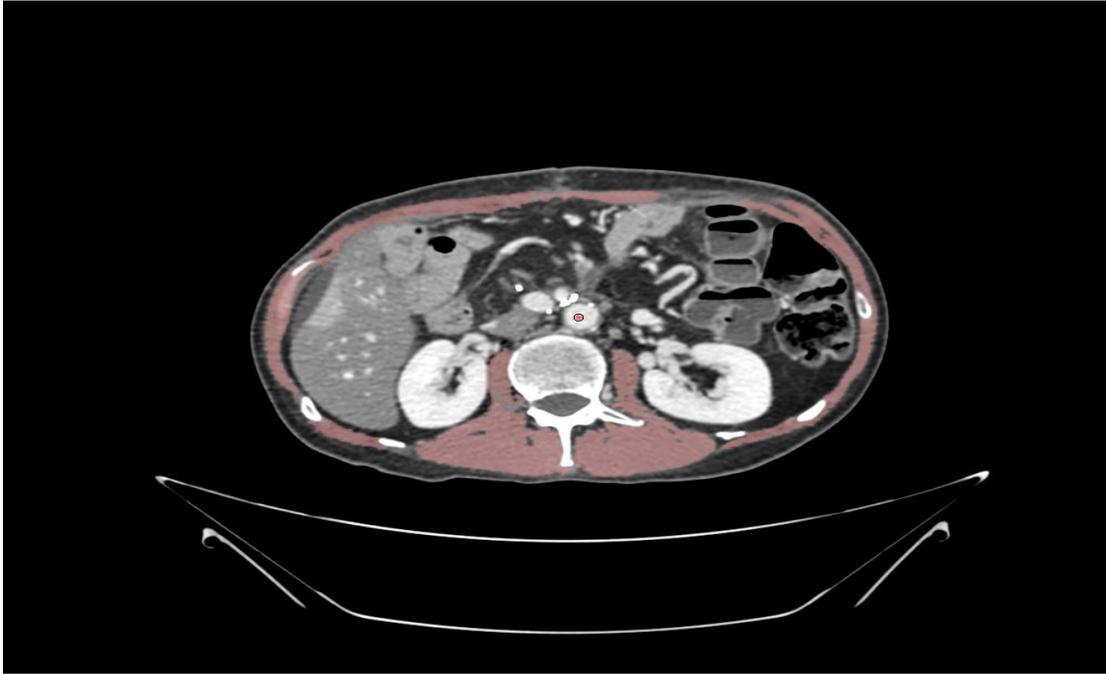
Total muscular surface on a L2-L3 CT section
